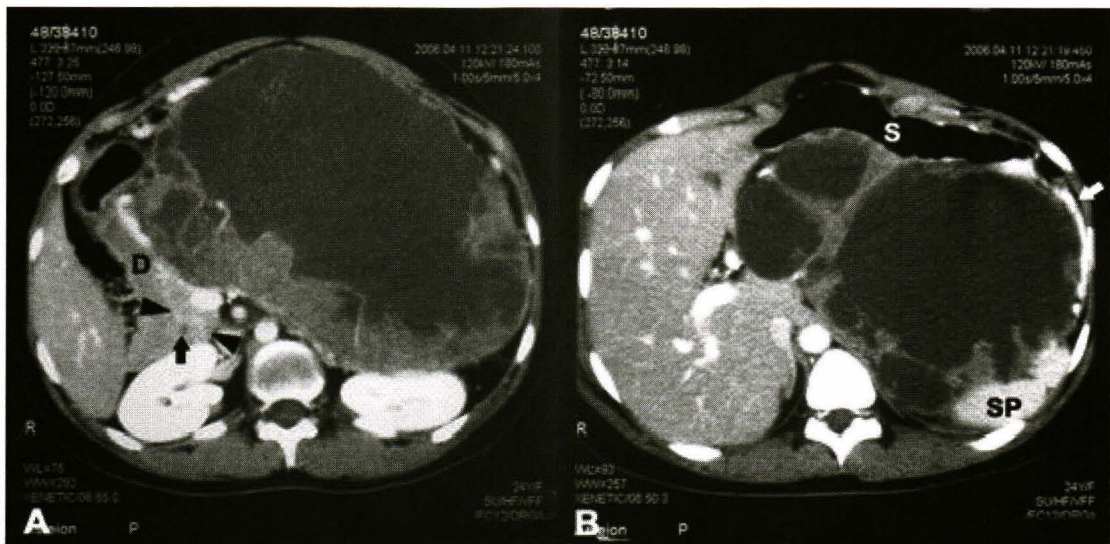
A) Contrast-enhanced CT of the upper abdomen shows a huge well-encapsulated cystic mass, containing enhancing irregular soft tissue component posteriorly at the body and tail of the pancreas, compressing the splenic vein. The head of the pancreas is normally visualized (black arrow heads). D = duodenum, black arrow = common bile duct; and B) This mass causes pressure and anterior displacement of the stomach (S). Dilatation of the short gastric vein is noted representing collateral (white arrow). SP = spleen
